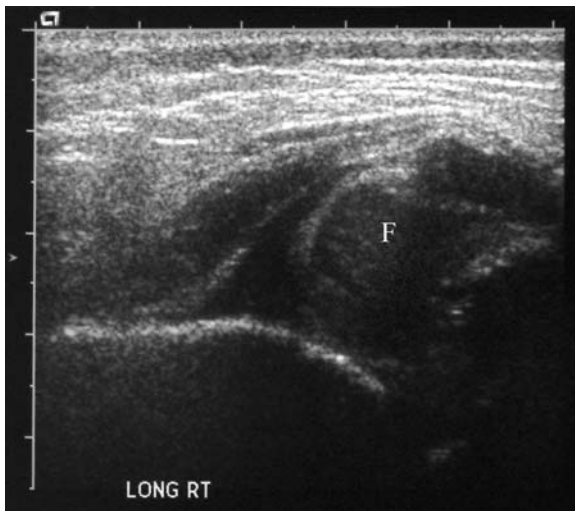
Longitudinal sonographic view of a dislocated infant hip.
